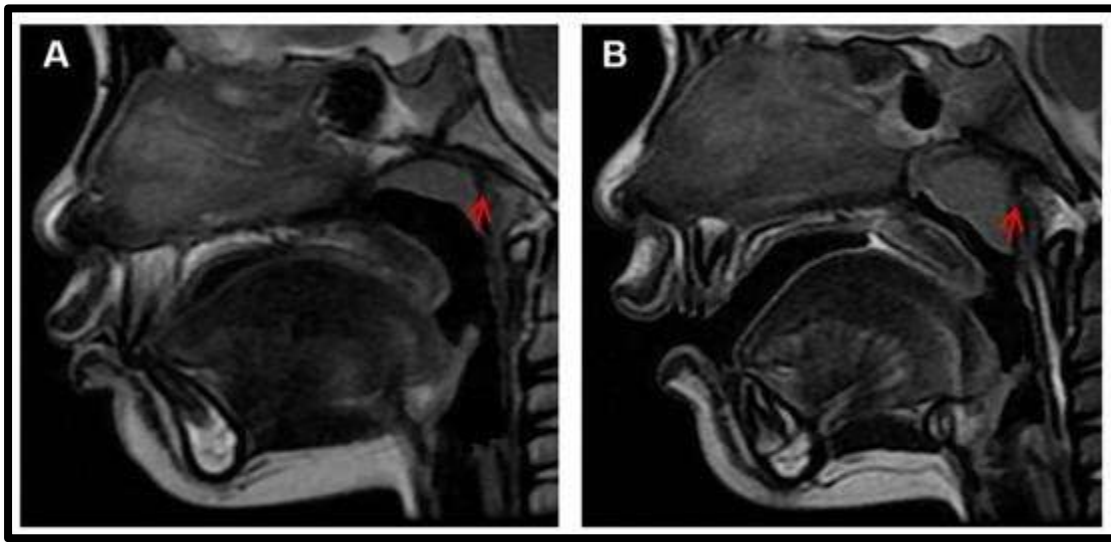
MRI Images of normal and hypertrophic adenoids.
